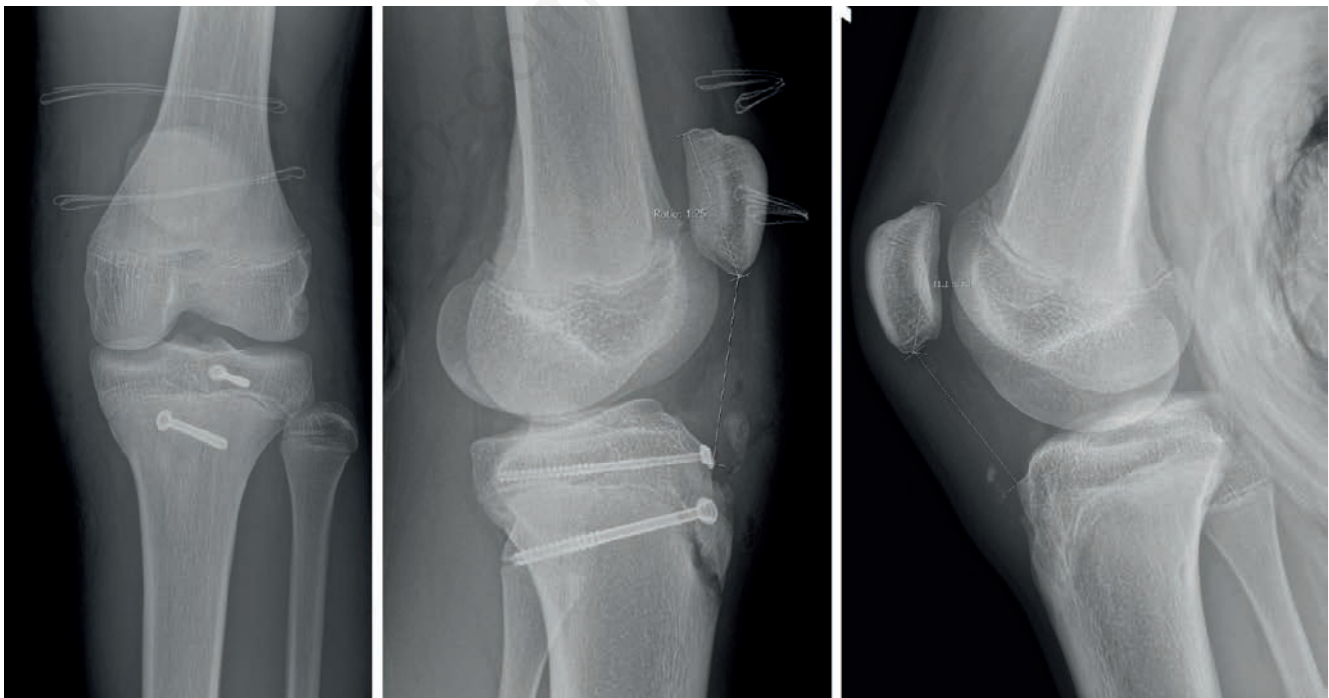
AP (left) and lateral (middle) postoperative radiographs showing an asymmetrically high-riding patella compared to the contralateral side (right). The IS ratio was 1.13 at the preoperative X-ray and 1.25 at the postoperative X-ray (middle).
